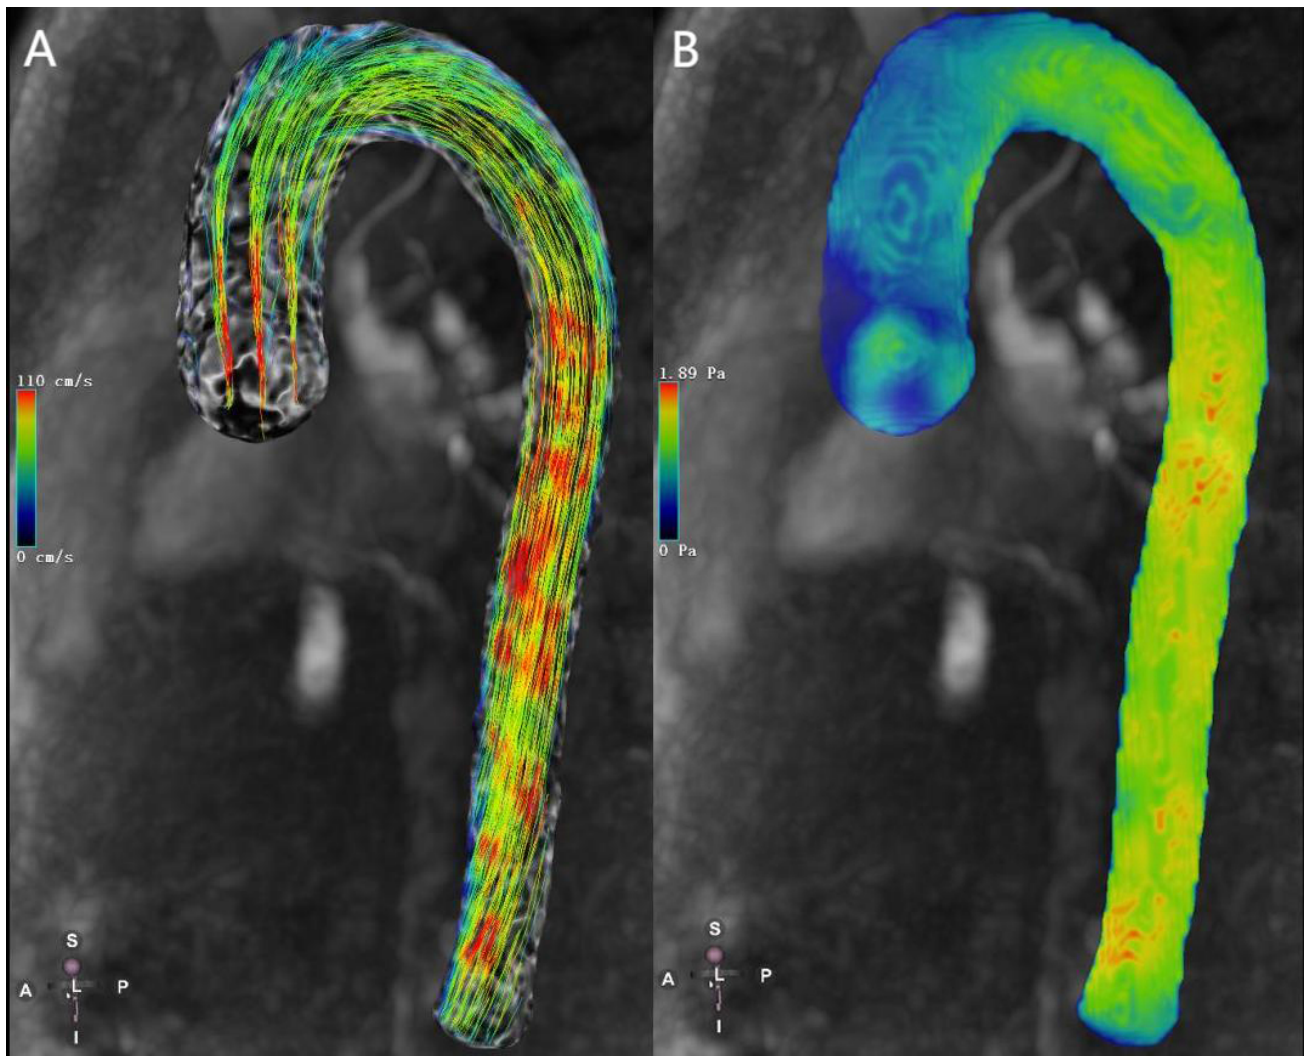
4D flow magnetic resonance imaging (MRI)–based visualization of aortic hemodynamics in a healthy volunteer. (A) 4D-flow-Image streamlines for the aorta. (B) 4D-flow-Image wall shear stress for the aorta. The color gradient change reflects the magnitude of velocity and wall shear stress (WSS). Red and blue are the maximum and minimum values, respectively. 4D, four dimensions.
